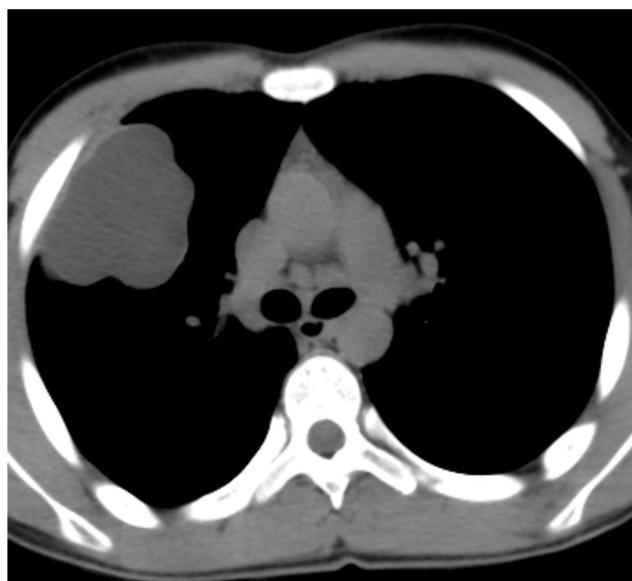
Pre-aspiration CT thorax showing a well defined cystic lesion in right upper lobe with 5–10 HU suggesting a fluid filled cyst.
